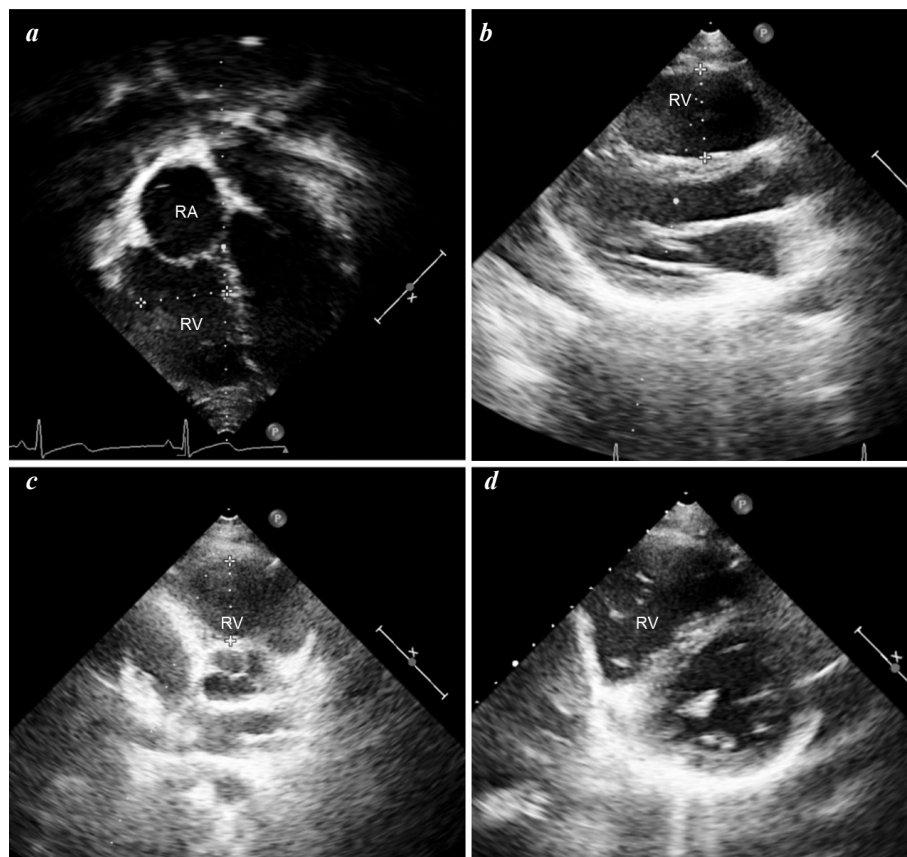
Echocardiography of a patient: a - four-chamber position, b - parasternal long axis, c - parasternal short axis, d - two-chamber position.
